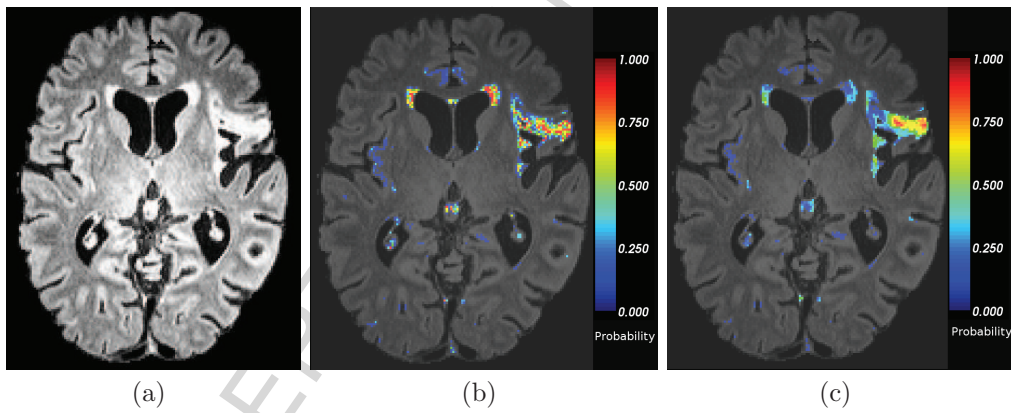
Likelihood and random forest probabilities of probable lesion areas. (a) Original FLAIR image; (b) The likelihood obtained from the 8-class EM of the probable lesion area shows heterogeneity in the probabilities; (c) probabilities obtained from random forest are smoother.
